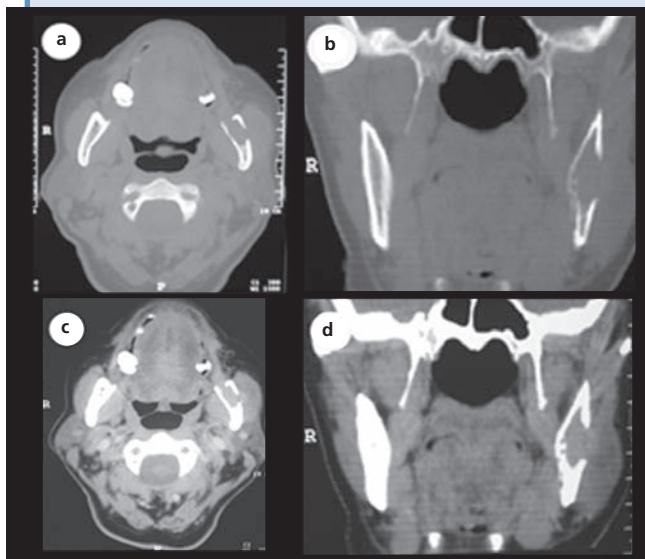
Axial and coronal CT scans showing involvement of the posterior aspect of the mandible in the retromolar region: (a) and (b) axial and coronal CT scans of bone involvement; (c) and (d) axial and coronal CT scans of a mass involving the mandible.
